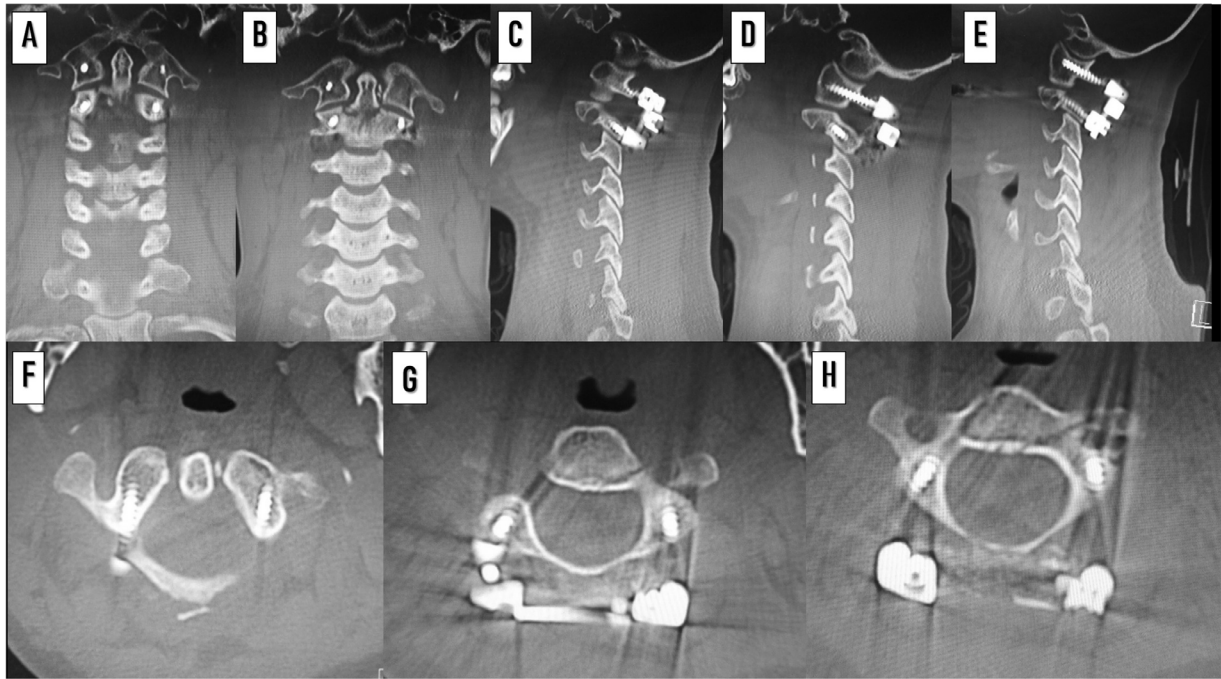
Post-operative CT scan images: coronal (A-B), sagittal (C-E) and axial (F-H).
